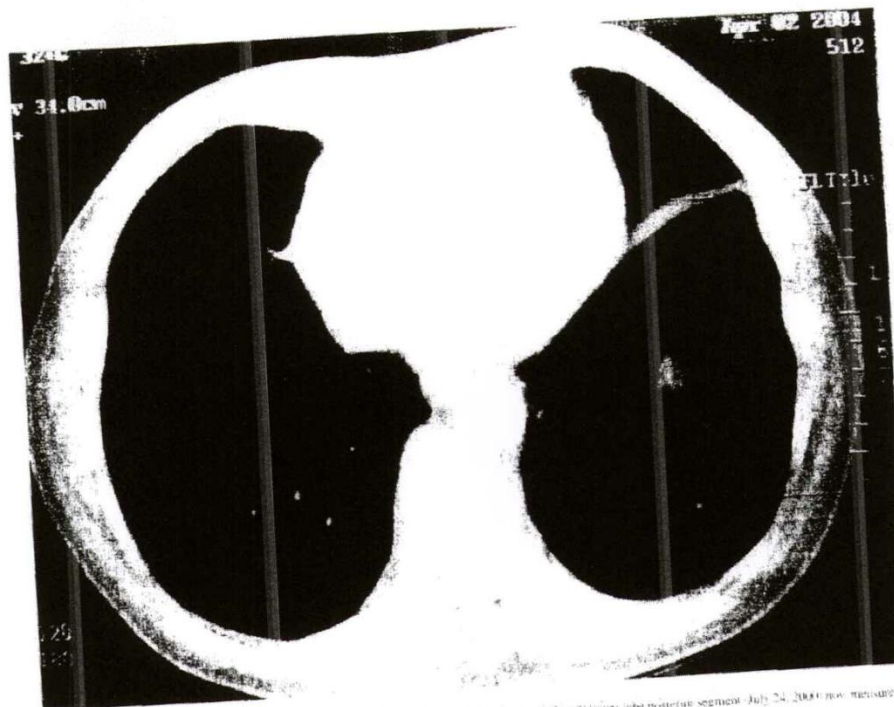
B. The thin-section CT scan was performed on April 2, 2004. The two masses shown on the left lower lobe posterior segment (July 24, 2000) now measure 1.4 x 1.4 cm (right) and 6.7 x 4.0 cm (left).
